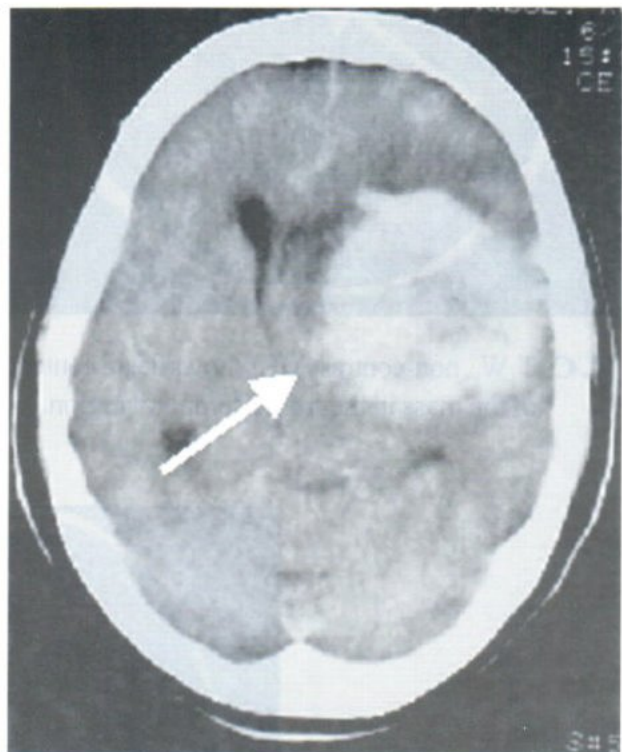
B Contrast enhancement CT. shows dense enhancing masses at left frontal lobe and one big dense enhancing mass at the fronto-temporal region.
